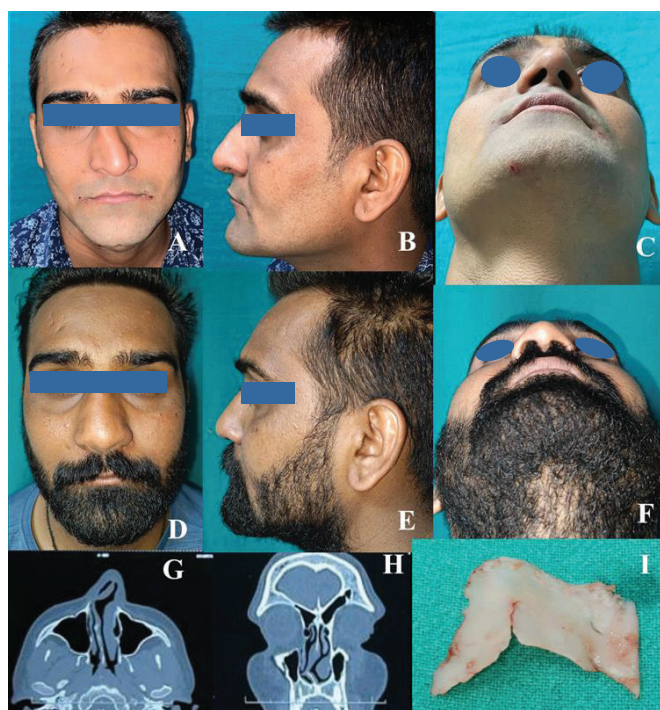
A. Preoperative, frontal view; B. Left lateral view; C. Worm's eye view; D. Three months postoperative, frontal view; E. Left lateral view; F. Worm's eye view; G. CT Scan axial section demonstrating gross deviation of septum in left-right and anteroposterior directions; H. CT Scan coronal section demonstrating gross deviation of septum in craniocaudal direction; I. The septal cartilage is thinned and grossly deformed.
